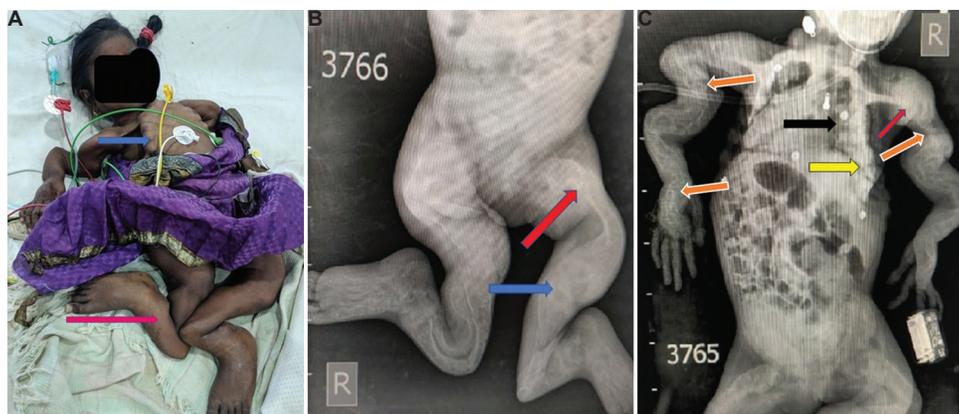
(A) Patient with deformed limbs (pink arrow), beaded ribs (blue arrow) and flail chest. (B) X-ray of the lower limbs showing reduced bone density, severe bony deformities with deformed gracile (blue arrow) and protrusion acetabuli with Coxa Vara. (C) X-ray of the upper body showing severe kyphoscoliosis (black arrow), multiple fractures (orange arrows), pectus excavatum with broad ribs (yellow arrow) and multiple healing fractures (red arrows).
